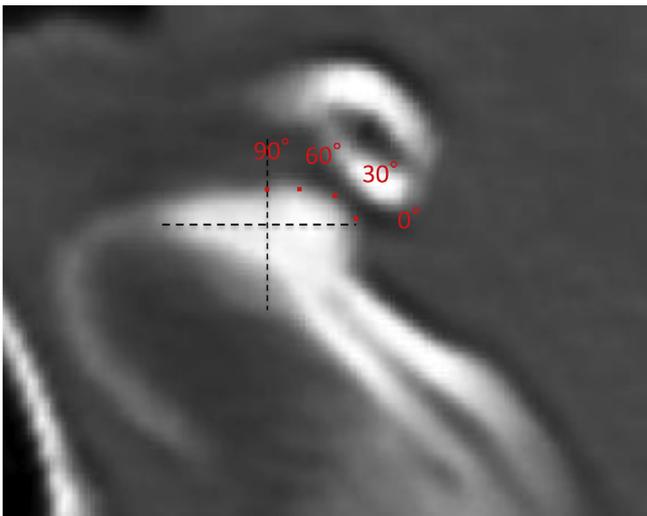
Measurements on computed tomogram (CT). Maximum CT values at the 0, 30, 60 and 90° sites of the condylar surface were measured.
